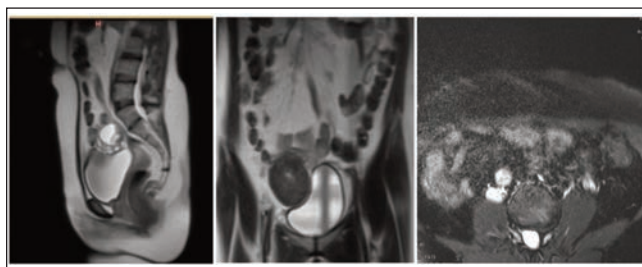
MRI scan right renal agenesis and adnexal cyst or endometriosis.
